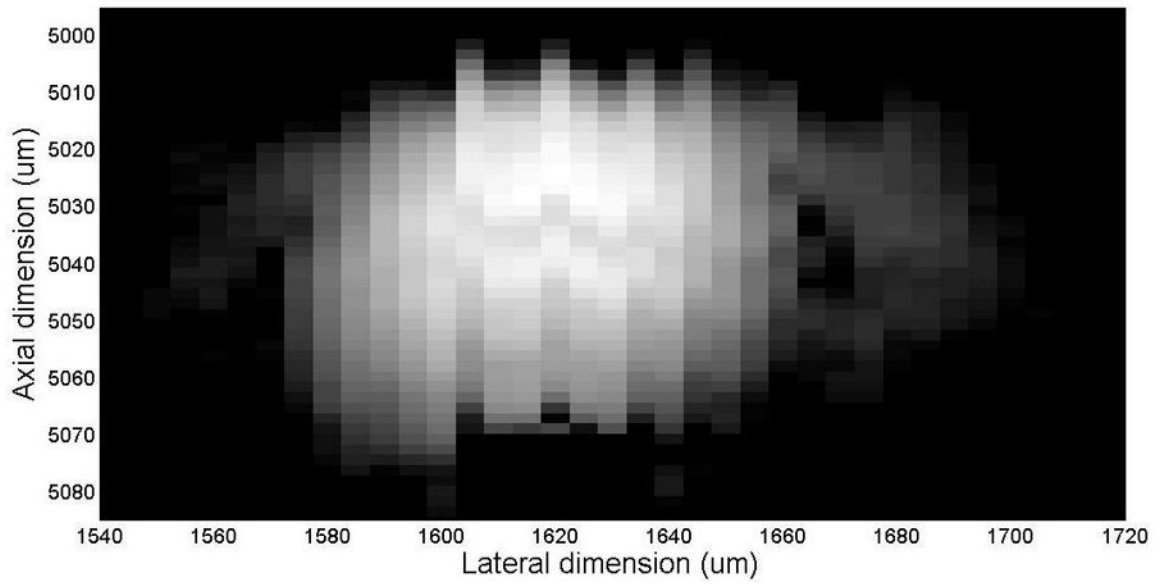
Ultrasound image of a cross-sectional scan of an 8 μm tungsten wire at the transducer focus, displaying the spatial distribution of the relative pressure amplitude from the 75 MHz focused transducer.
